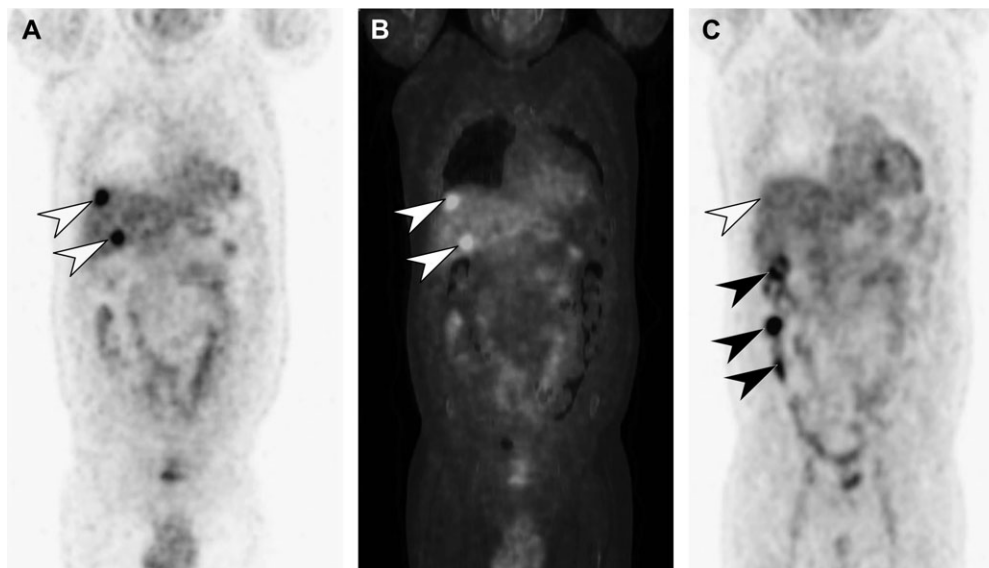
Assessment of response to chemotherapy. Pre-treatment coronal PET (A) and integrated coronal FDG-PET/CT (B), showing 2 metabolically active lesions in the liver (white arrows). Post-treatment coronal FDG-PET (C) shows complete metabolic response in these liver lesions (white arrow), with physiologic uptake in normal bowel (black arrows).
